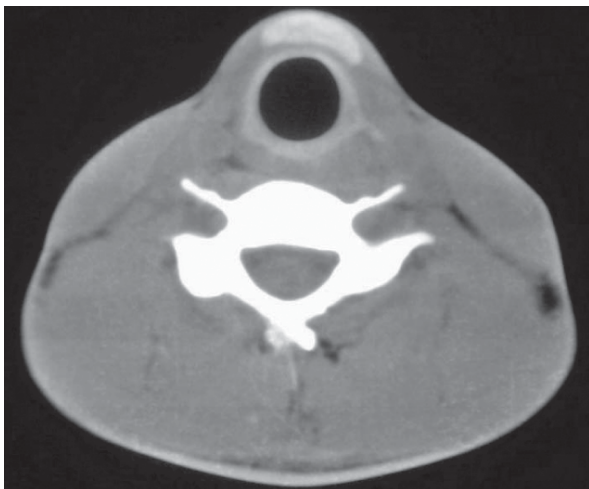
CT scan of neck showing agenesis of both the lobes with hyperplastic isthmus.
